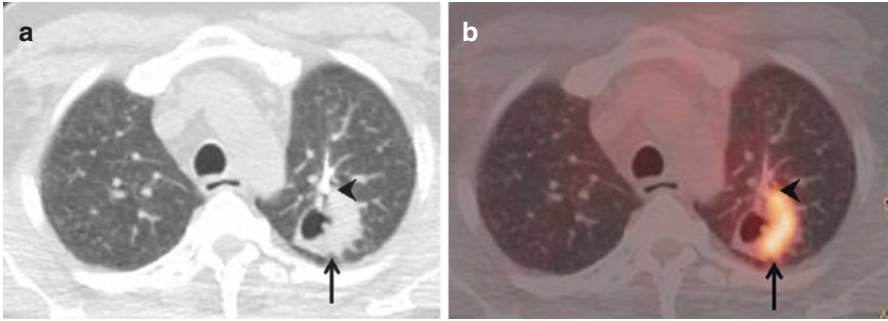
Axial CT and fusion PET/CT (arrows in a, b) images show a cavitating lung neoplasm
